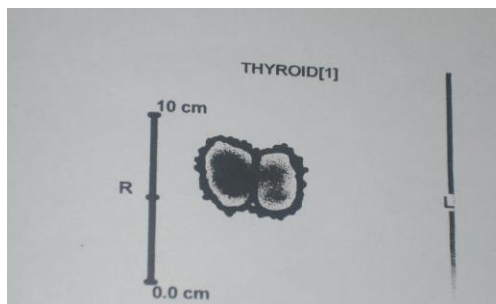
The ^{99m}Tc thyroid scintigraphy exhibits a "hot" nodule in the right thyroid lobe and two additional hot nodules in the left lobe.
